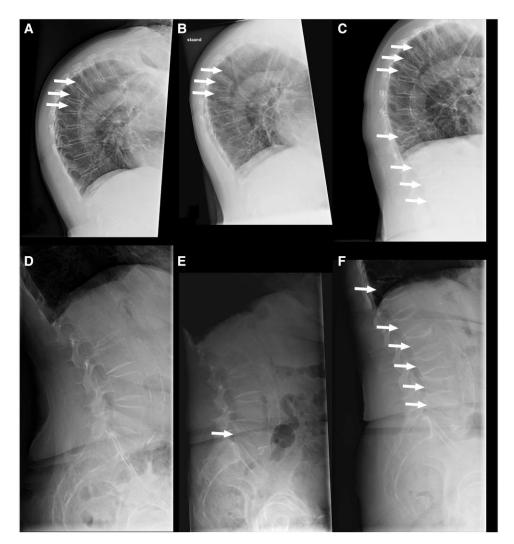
Spine x-rays of the A to C, thoracic and D to F, lumbar spine with arrows indicating the vertebral fractures. A and D, At presentation at our outpatient clinic. B and E, One month before starting and C and F, 1 month after finishing 1-year treatment with romosozumab.
